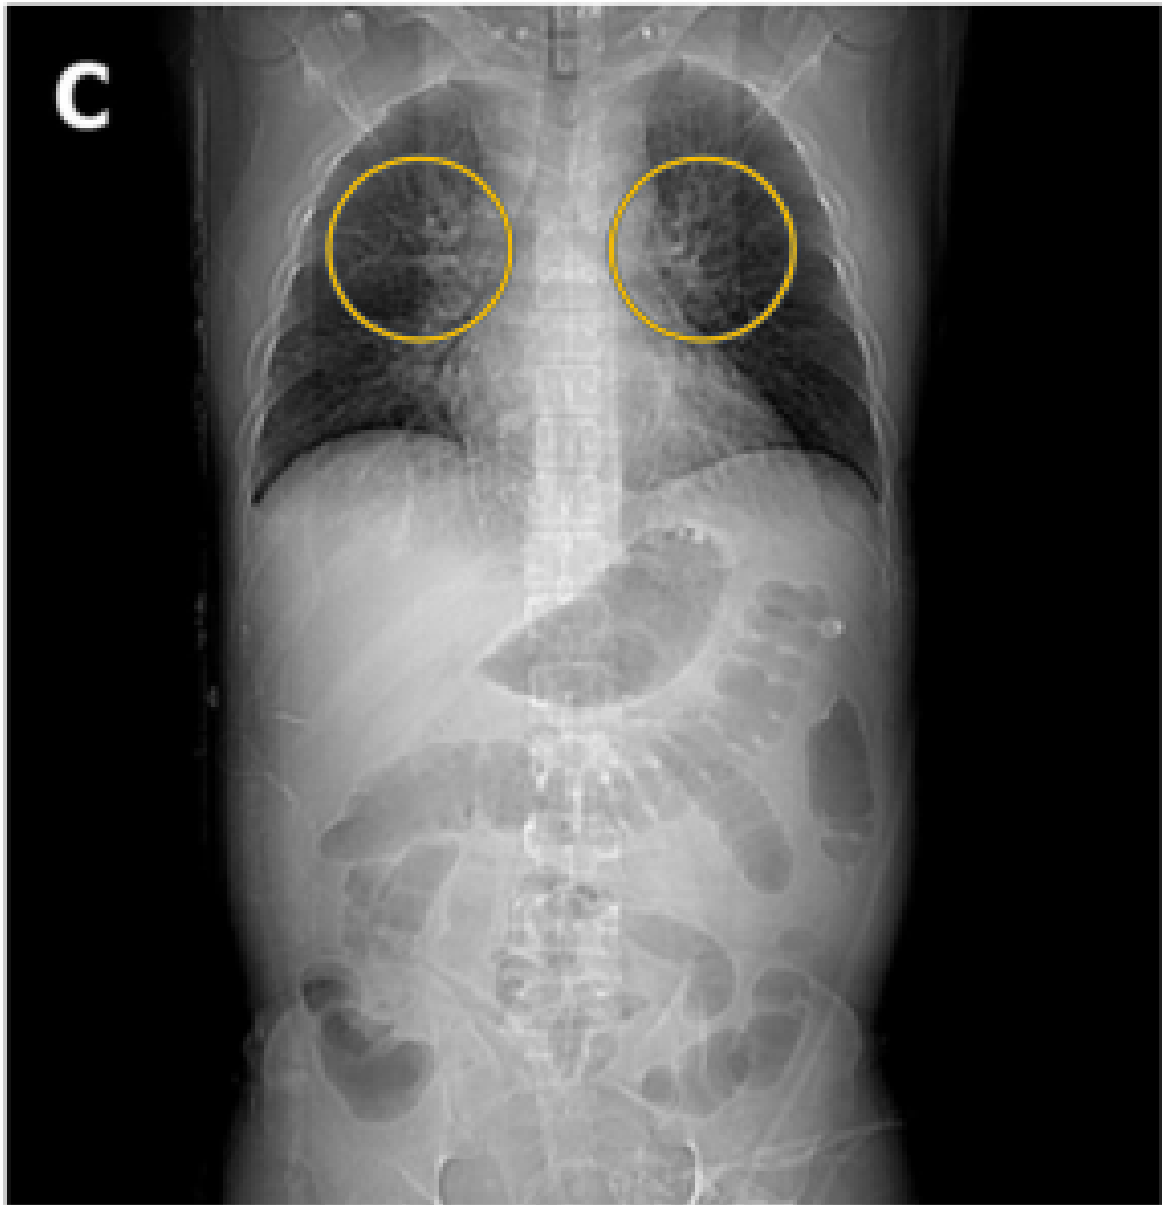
C. An abdominal CT scan suggested cardiac dysfunction with pulmonary edema.¹ (Yellow circle showing batwing sign of pulmonary edema.⁶)
